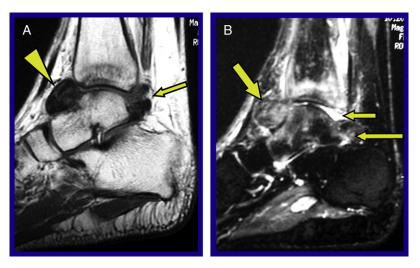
(*A*) MRI T-1 imaging sagittal section reveals a prominent multi nodular synovial–based mass predominantly situated in the anterior ankle (arrow head). There is a bifid nodule within the posterior ankle capsule that emits a nonhomogeneous signal intensity and is best appreciated in the T-1 imaging sequence (small arrow). (*B*) MRI Split Tau Inversion Recovery (STIR) sequence sagittal section reveals the mass within the anterior ankle juxtaposed to the dorsum of the talar neck. The inflammatory process appears most intense within the distal tibia with intra medullary edema less intense throughout the talus. The morphology and the location of the anterior ankle mass are commensurate with scalloping of the dorsal talar neck appreciated on plain radiographs (fat arrow). The fluid within the posterior hiatus (small arrow) and the mixed signal intensity within the bifid nodule in the usual location of the os Trigonum (long arrow) are evident within this STIR sequence image.
